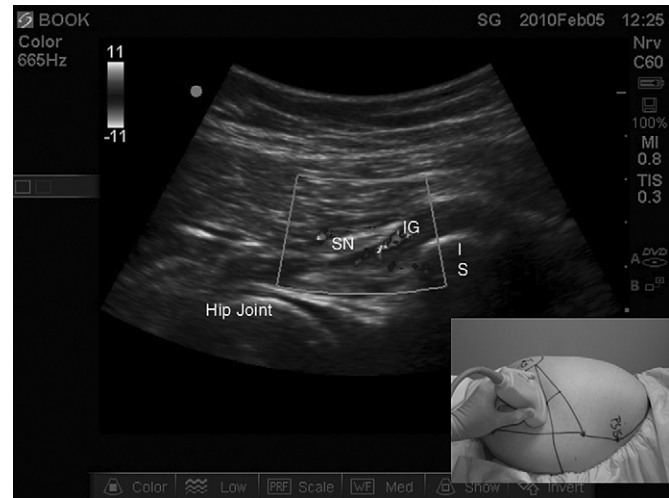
Ultrasonography of the parasacral sciatic nerve in long axis. SN = sciatic nerve; PM = piriformis muscle.
